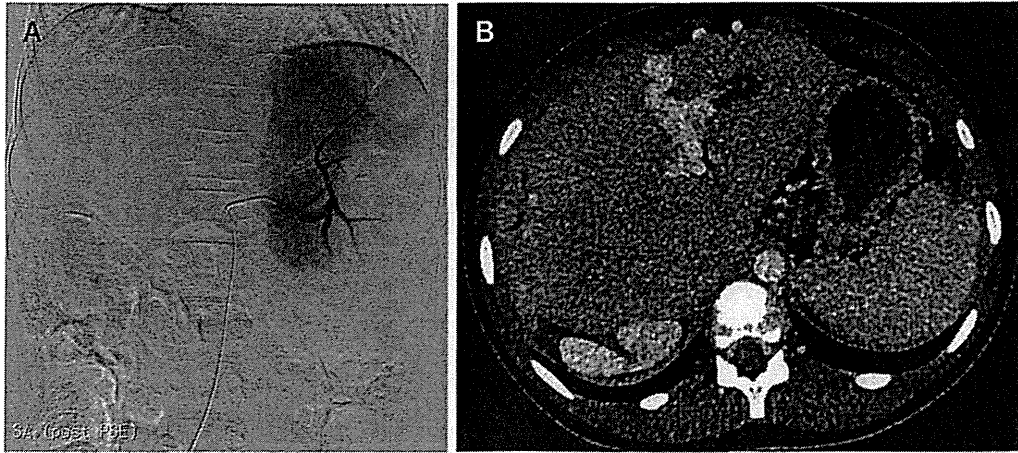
PSE 後の血管造影 (A), PSE 施行後 1 年の CT (B)
